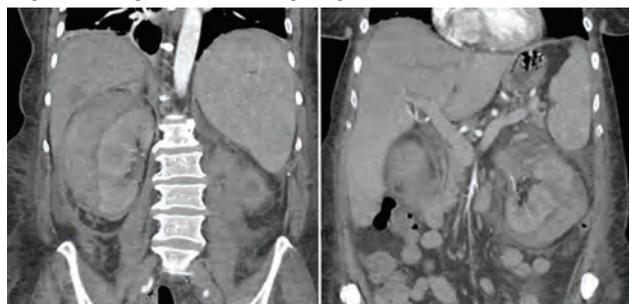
CT with contrast showing bilateral perinephric hematomas.
